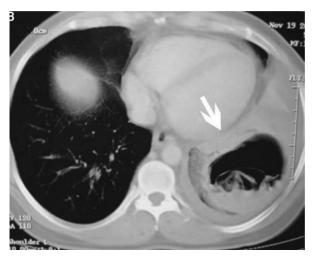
Contrast-enhanced CT chest scan showing a cyst in the left lower lobe of the lung containing a freely floating endocyst (the "water lily sign"). (Reprinted with permission from Khanna et al. 46 © Copyright 2007 The Medical Journal of Australia)
